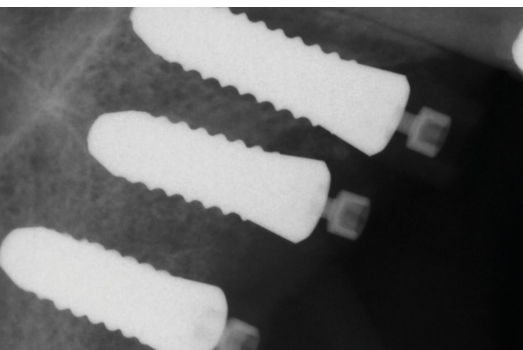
X-ray after four months of healing with complete bone remodeling.
